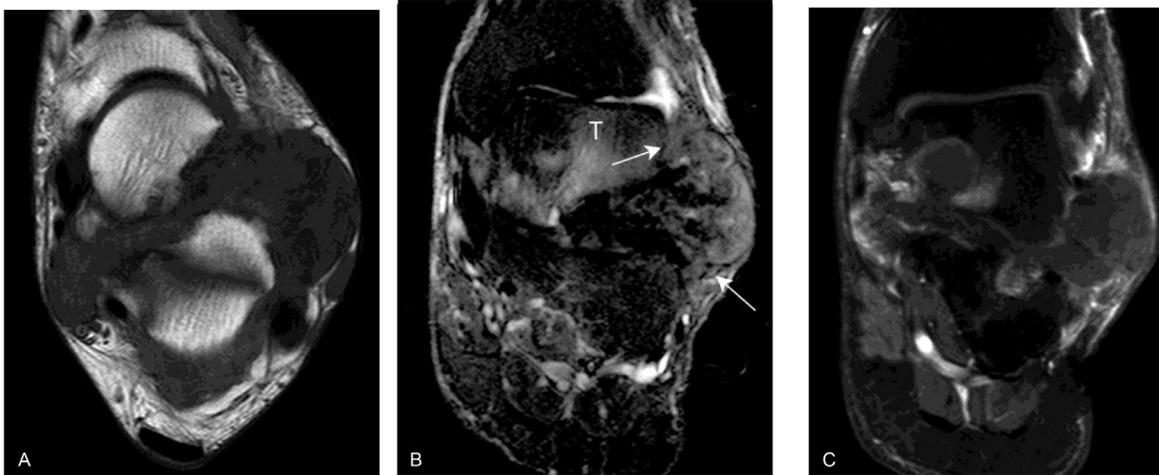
Gout. (A) Axial T1WI shows intra-articular mass involving the sinus tarsi. (B) On coronal short-axis fat saturated T2WI, the lesion is hypointense (white arrows), associated with marrow edema and erosion at the talus (T). (C) Coronal short-axis fat saturated postcontrast T1WI shows peripheral rim enhancement of the intra-articular mass. T1WI, T1-weighted images; T2WI, T2-weighted images.
